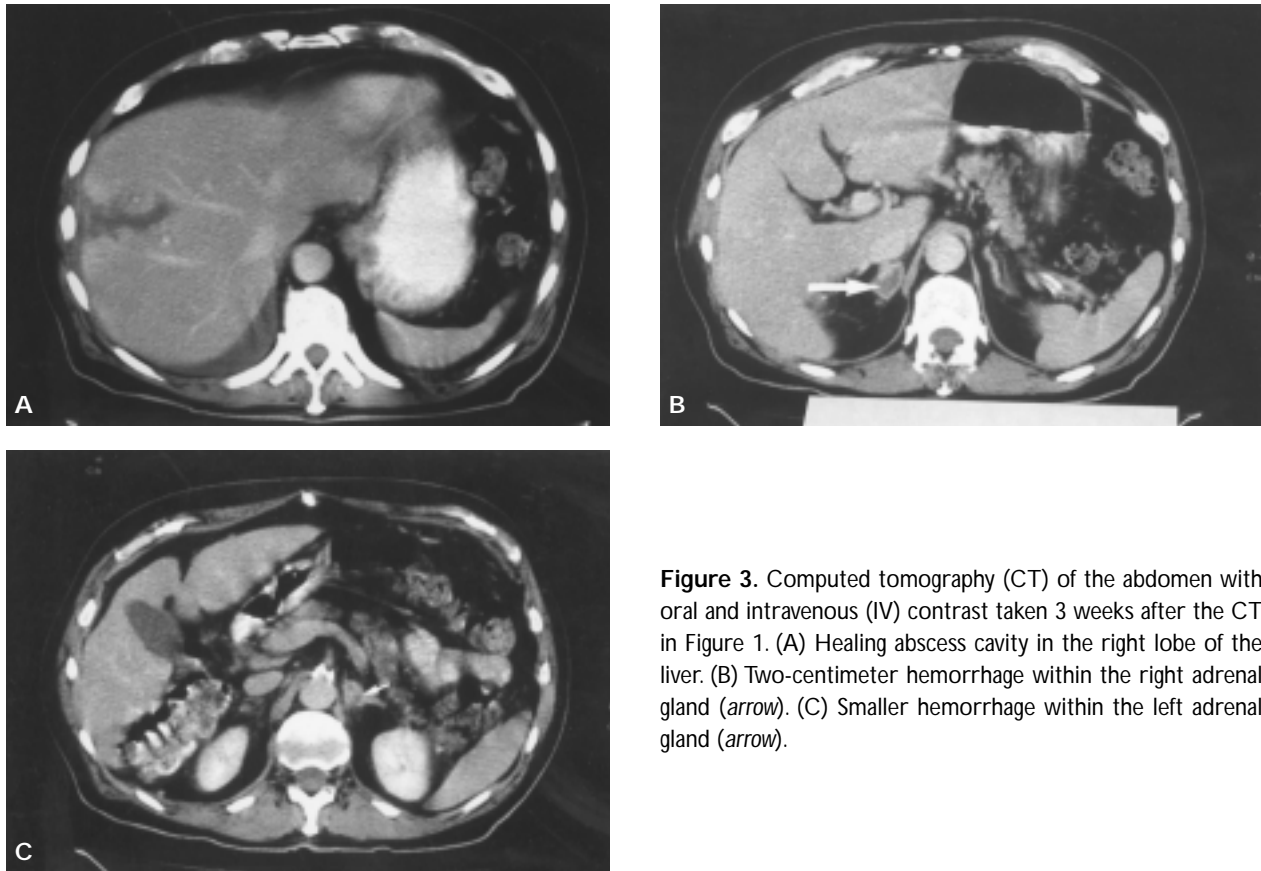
Computed tomography (CT) of the abdomen with oral and intravenous (IV) contrast taken 3 weeks after the CT in Figure 1. (A) Healing abscess cavity in the right lobe of the liver. (B) Two-centimeter hemorrhage within the right adrenal gland (arrow). (C) Smaller hemorrhage within the left adrenal gland (arrow).
